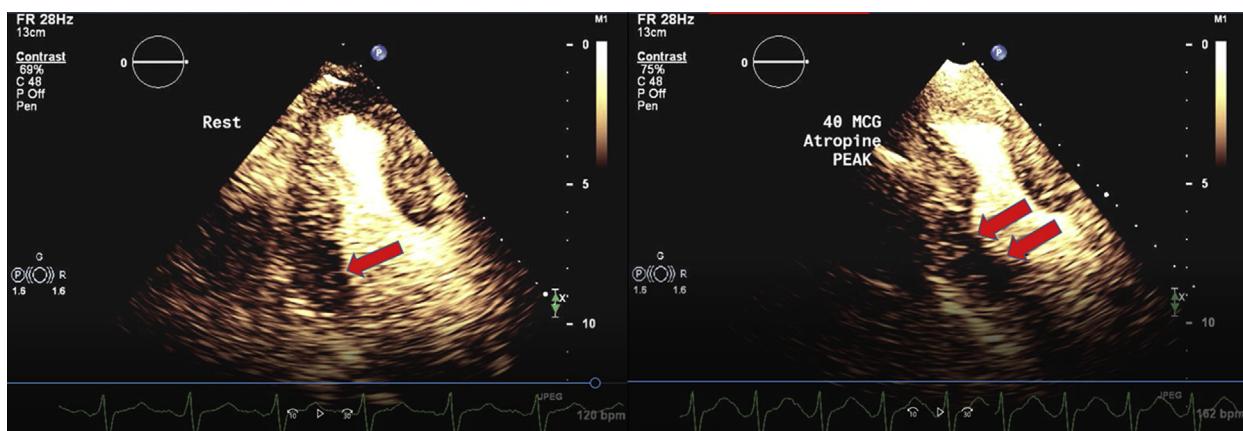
End-systolic apical three-chamber view still frames during RTMCE examination in a patient with grade 2 CAV, at rest (left) and during peak dobutamine stress (right). Resting perfusion is slightly delayed in the basal inferolateral wall (arrow), possibly due to basal attenuation. At peak stress, a well-demarcated subendocardial perfusion defect (arrows) is present (see [Supplemental Video 1](#) for corresponding RWM assessment).
